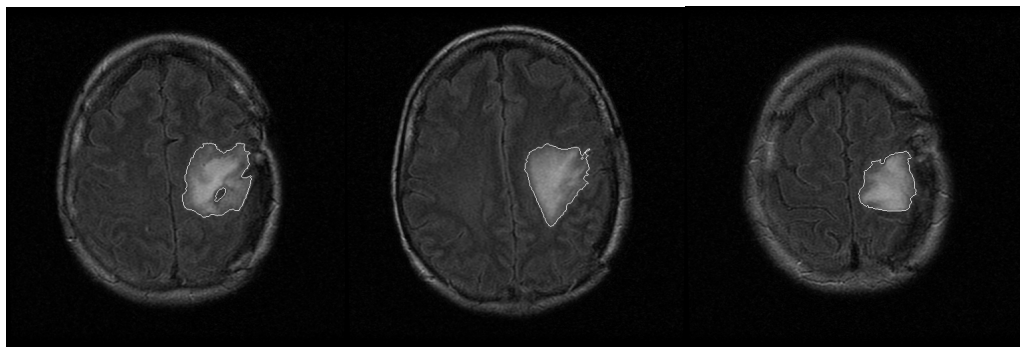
Examples of ACM effect on Patient 1 (FLAIR images)
